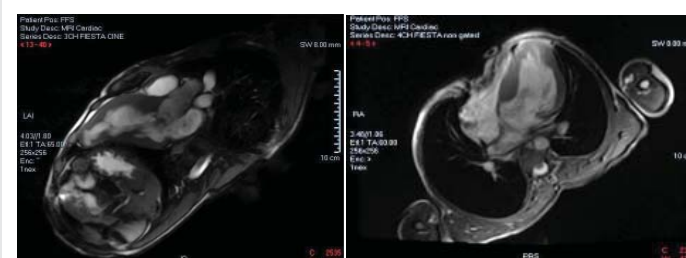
Cardiac Magnetic Resonance imaging (CMR) demonstrating increased Interventricular Septal (IVS) and Right Ventricular (RV) wall thickness.
